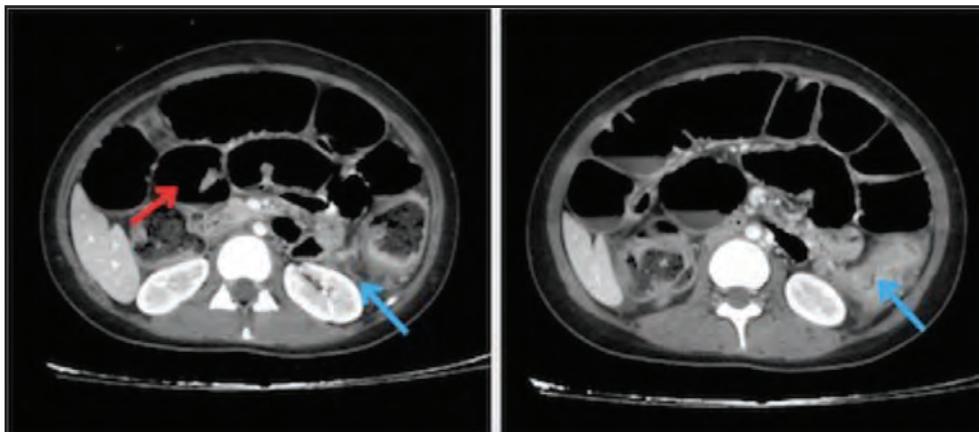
Pre Surgery Abdominal CT Scan with contrast (Blue arrow: Descending colon tumor ; Red Arrow: Bowel dilatation from the proximal part of the liver)
